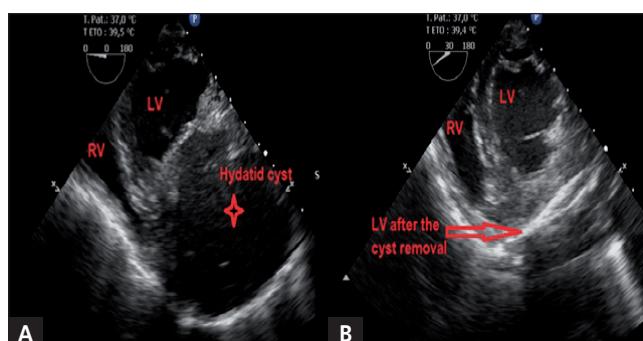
Transgastric short axis view in the transesophageal echocardiography demonstrating the LV before (A) and after the cyst resection (B).
